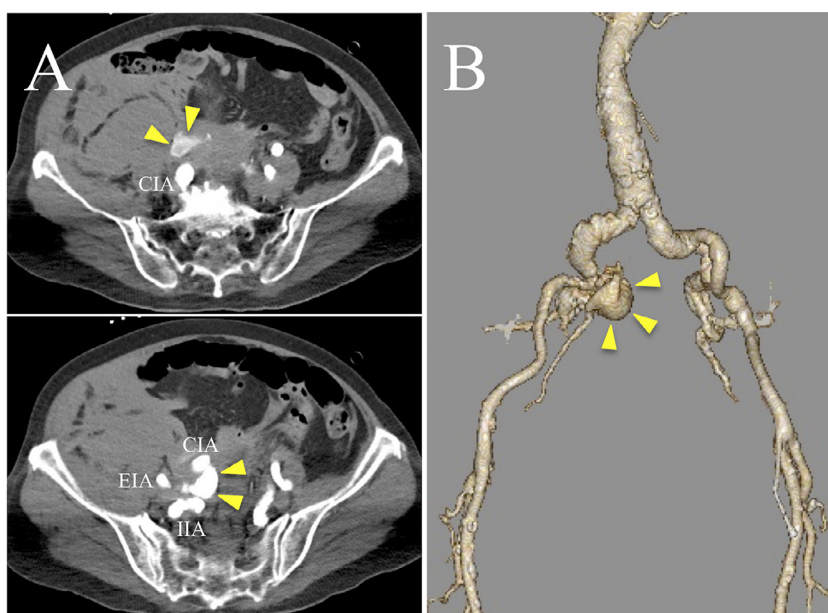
Emergency contrast CT performed to diagnose hemodynamic instability after coil embolization revealed a severe retroperitoneal hemorrhage due to extravasation from the right iliac artery (A). The 3-dimensional CT angiography revealed the high degree of tortuosity at the site of bleeding in the right iliac artery (B).
